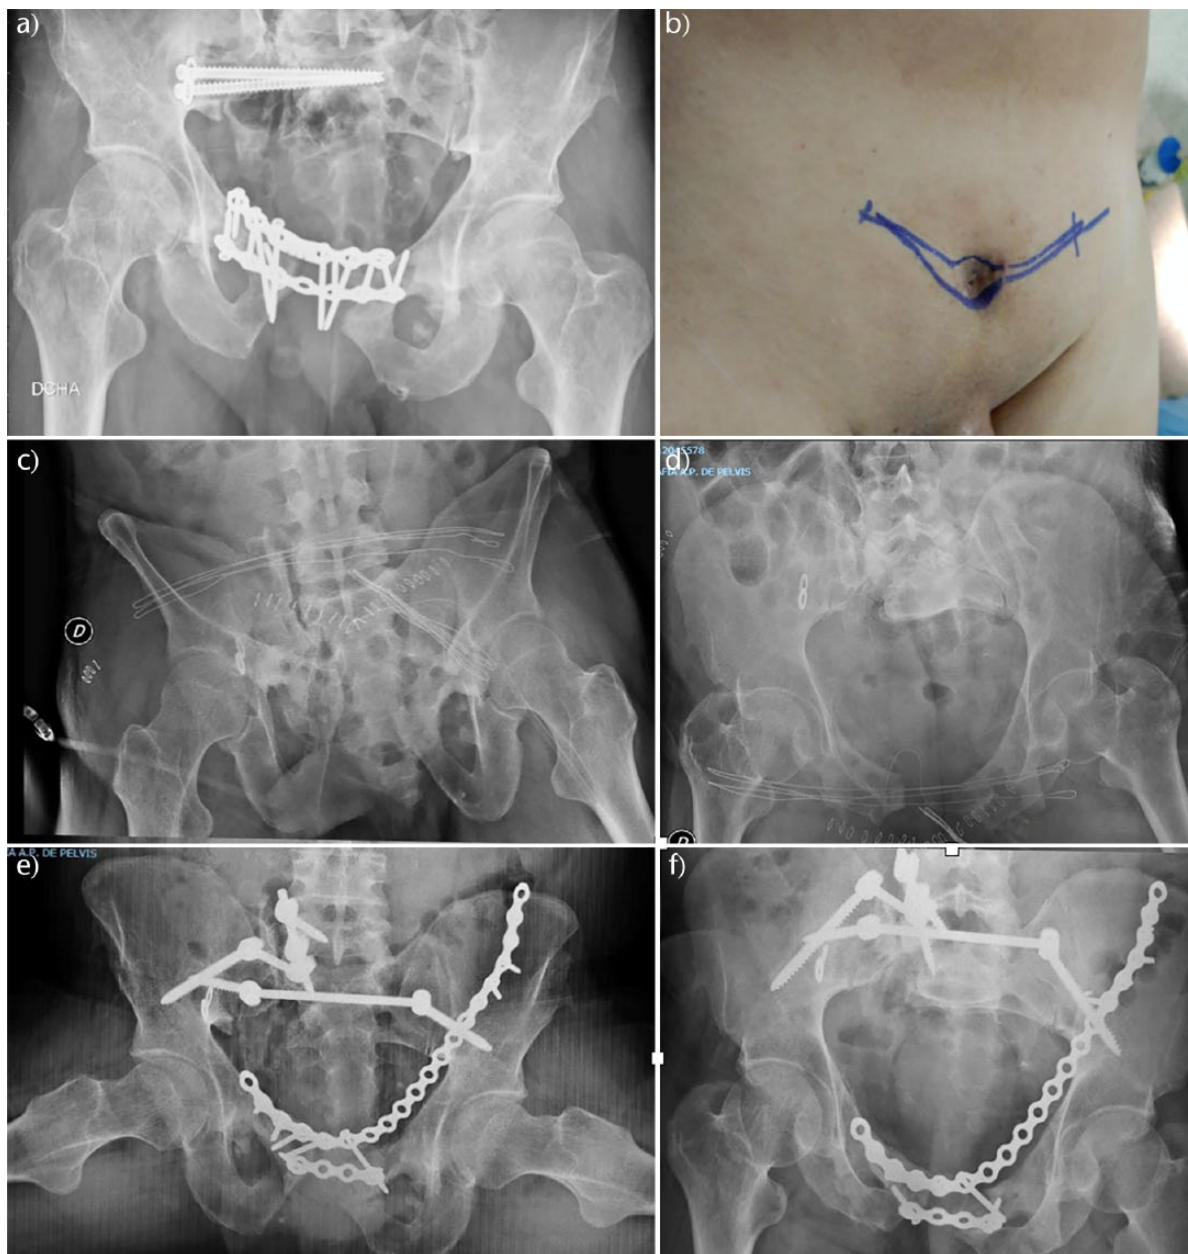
Type II complex instability with associated deformity and septic nonunion: a) preoperative radiograph; b) clinical photography showing fistula over previous Pfannenstiel approach; c) and d) postoperative radiograph after sequential liberation surgery and correction of the deformity; e) and f) radiograph control after four years of follow-up.
